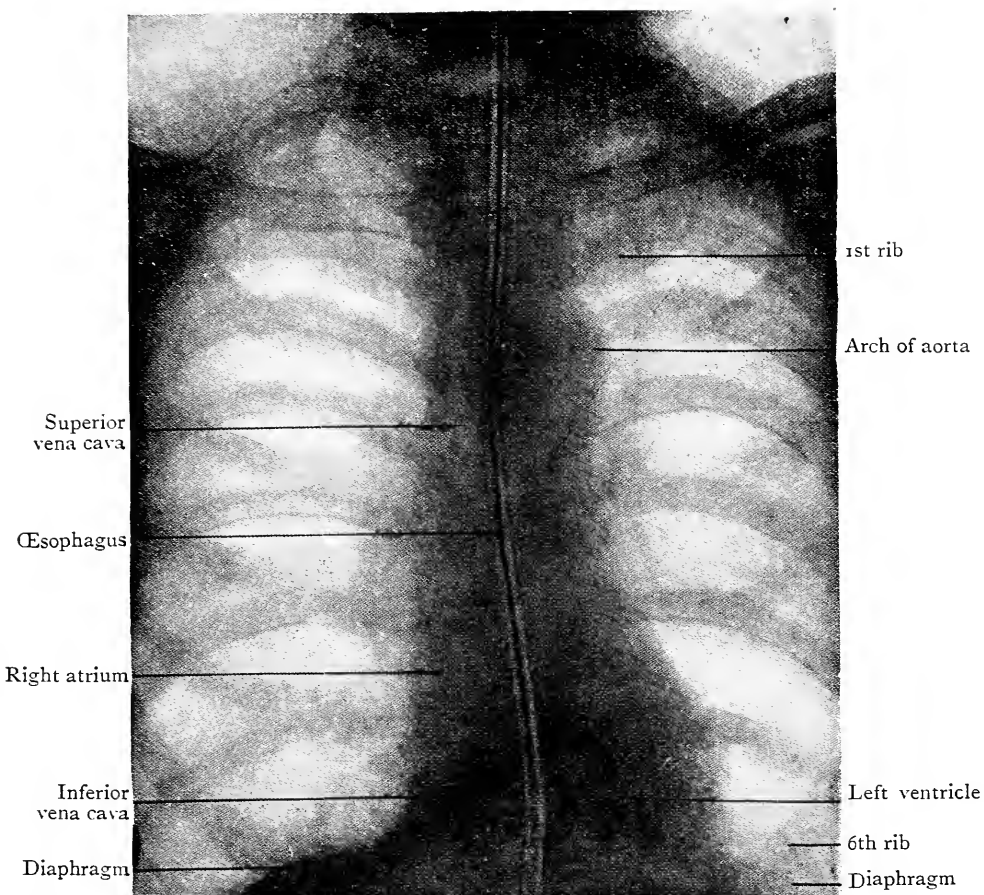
Radiograph of the Thorax, showing the position of the Esophagus into which a bougie with a metal core had been inserted. Anterior view. (Goldesbrough.)
